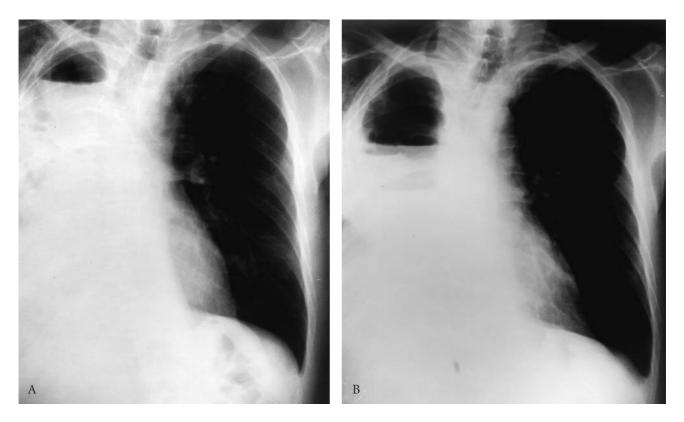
A, Chest radiograph, 5 days after right pneumonectomy, with typical high air-fluid level. B, Chest radiograph of the same patient, 1 day later after cough and dyspnea were reported by the patient. Notice the drop in the air-fluid level. Subsequent investigation demonstrated a very small bronchopleural fistula.
